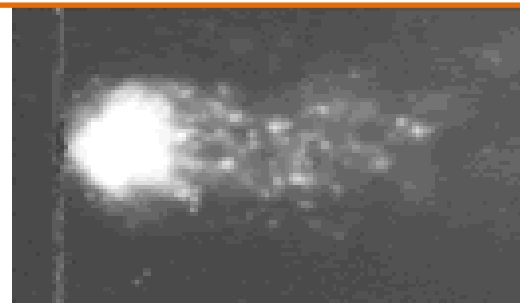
X-ray calibration 25.6 rads. DNA breaks are very obvious
